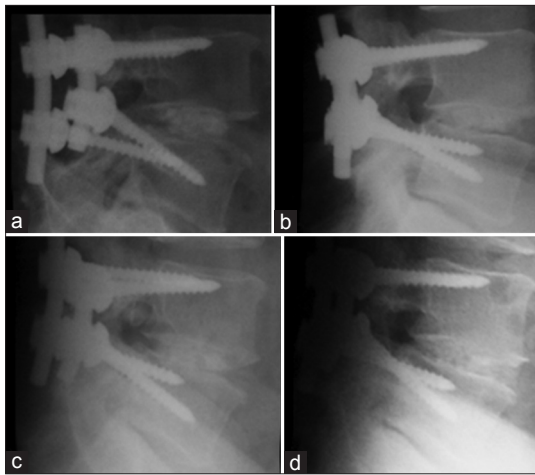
Follow-up X-ray images (a = 0, b = 3, c = 12, and d = 24 months, respectively) showing fusion but at the same time reduction in the disc (autologus bone graft)
